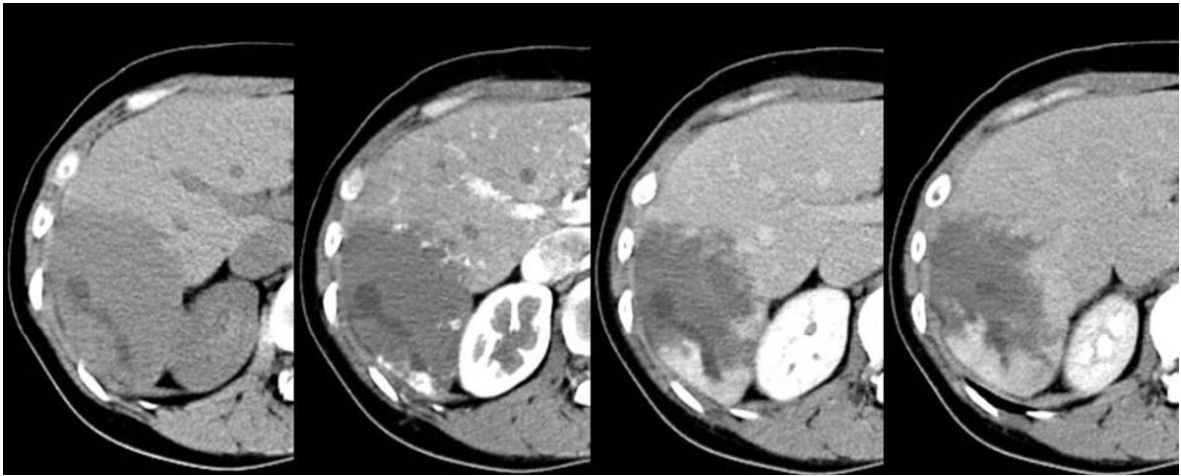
CT scan showing peripheral nodular enhancement of hypodense lesion with delayed centripetal filling suggestive of haemangioma.
